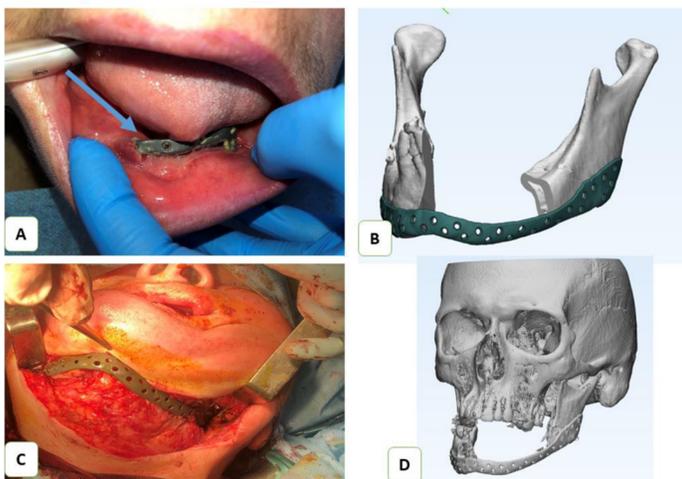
Patient P. A: Graft fragment erupted into the oral cavity (blue arrow); B: 3D model of the patient-specific implant (PSI); C: Intraoperative view of mucous membrane defect in the lower jaw; D: Postoperative CT scan showing restored mandible configuration and joint function.⁹⁵ (Permission under the CC BY-NC-ND license).
